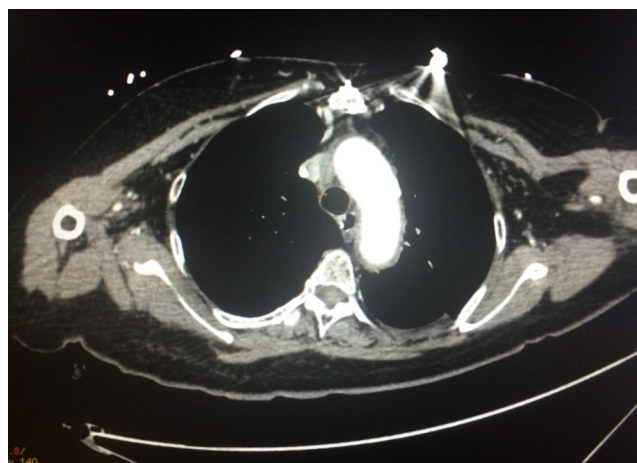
High resolution chest CT showing no evidence of recurrent anterior or superior mediastinal mass
